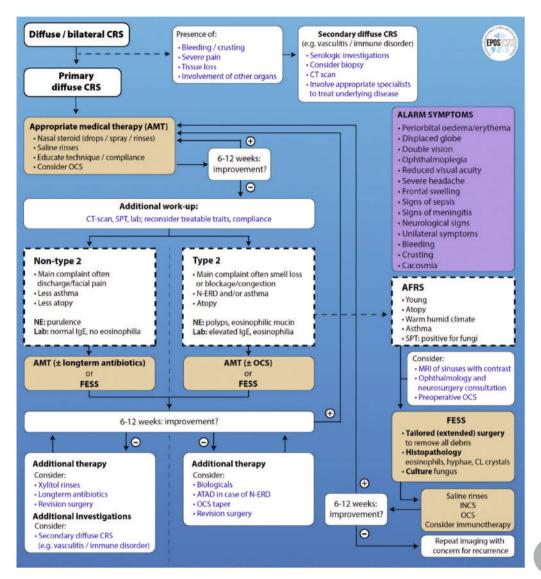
EPOS 2020 treatment scheme for CRS. Reproduced with permission from the authors. AFRS, allergic fungal rhinosinusitis; ATAD, aspirin treatment after desensitization; CL, Charcot Leyden; CRS, chronic rhinosinusitis; CT, computed tomography; FESS, functional endoscopic sinus surgery; INCS, intranasal corticosteroid; MRI, magnetic resonance imaging; NE, nasal endoscopy; N-ERD, nonsteroidal anti-inflammatory drug exacerbated respiratory disease; OCS, oral corticosteroid; SPT, skin prick test.
